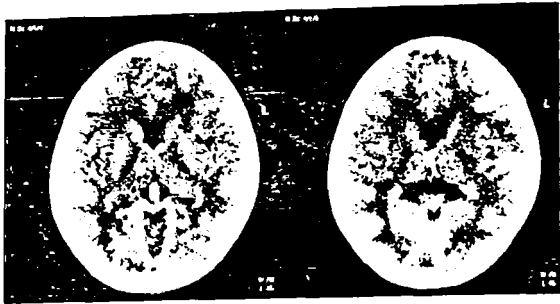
Preoperative, postcontrast, serial CT scan axial images of the same patient.
